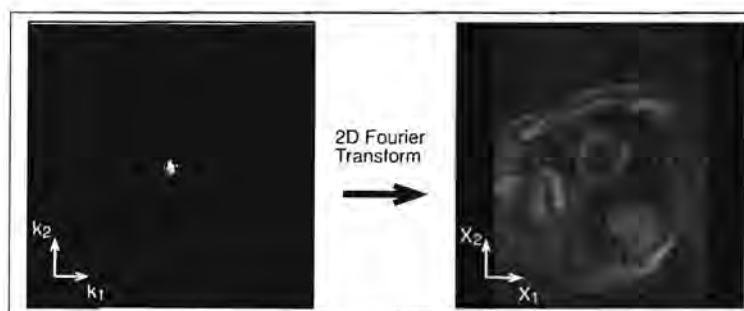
Example of k-space data and its associated image for a 2D acquisition A) k-space, B) MRI image.
